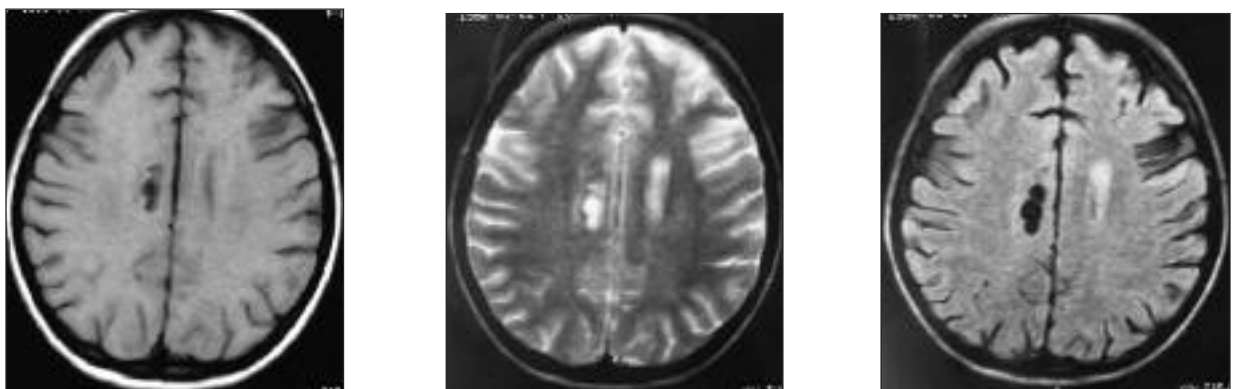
Bilateral periventricular Type-II VRS dilatations are seen on cerebral axial T1-weighted MR image.
